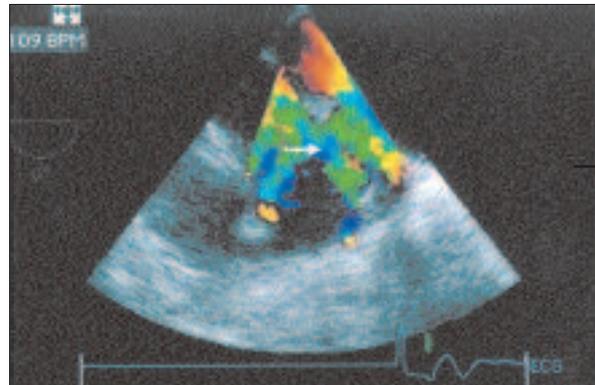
Doppler image shows shunt flow passing from the aorta into the pulmonary artery (arrow).
